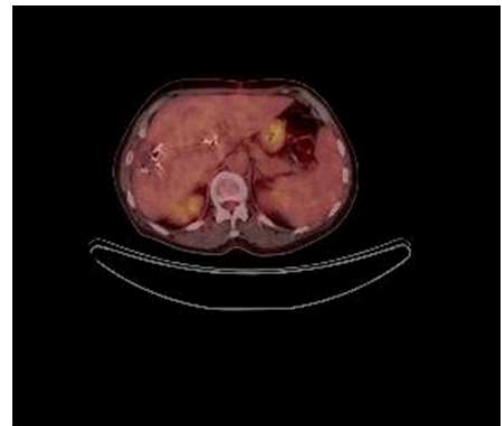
Postoperative PET-CT scan shows no tumor recurrence at segment 6 resection location.
